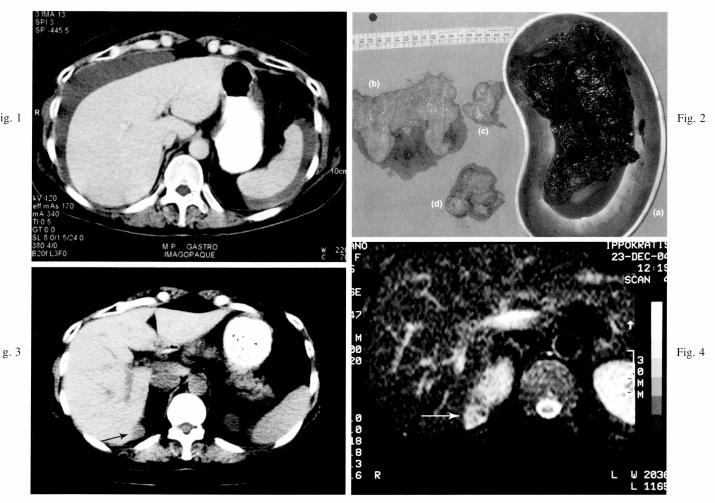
CT scan of the abdomen demonstrating haemoperitoneum.
